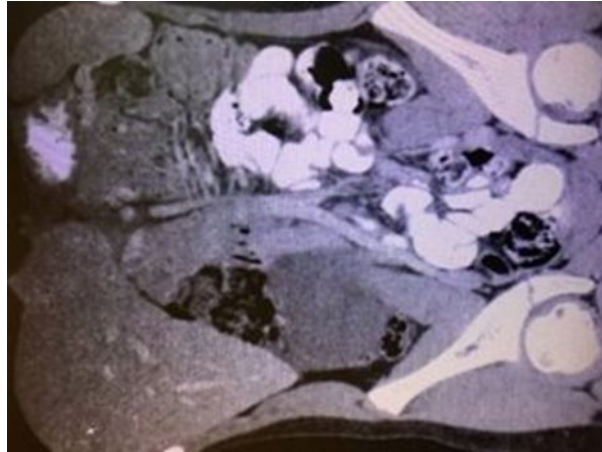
Mesenteric and omental cysts will appear as a fluid filled cyst on CT and ultrasound
